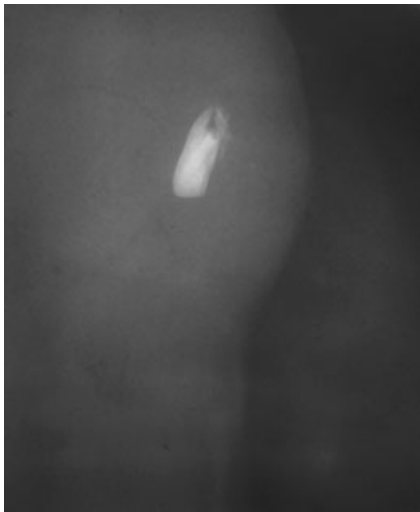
Radiograph of the lower lip. The tooth fragment is seen embedded in the lip.
